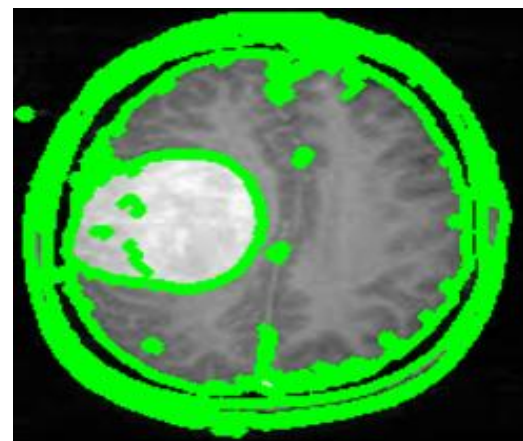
Edge Detected Brain MRI Image
